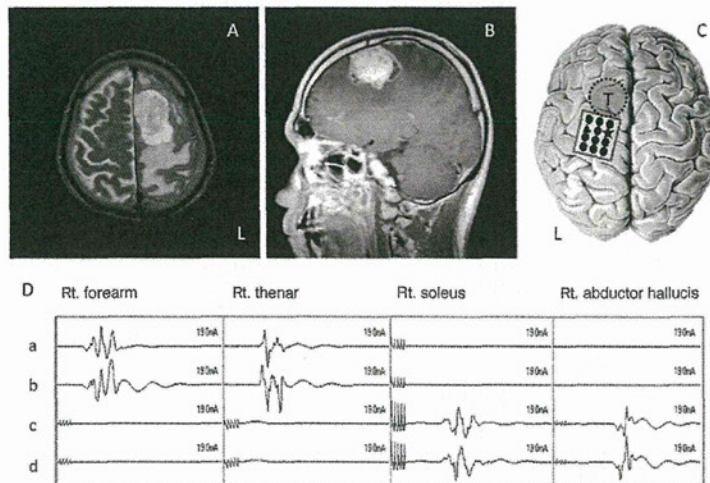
Axial T2-weighted MR image (A) and sagittal Gd-enhanced T1-weighted MR image (B) of a patient (case 6) with a parasagittal meningioma. A 4×3 grid was placed directly on the motor cortex to cover the entire precentral gyrus (C). The stimulation sites for the lower and upper limb MEPs are indicated by an asterisk and a triangle, respectively. The location of the tumor is indicated by a T and a dashed circle. MEPs (D) were successfully recorded from the muscles of the upper (a and b) or lower (c and d) extremities, respectively.
